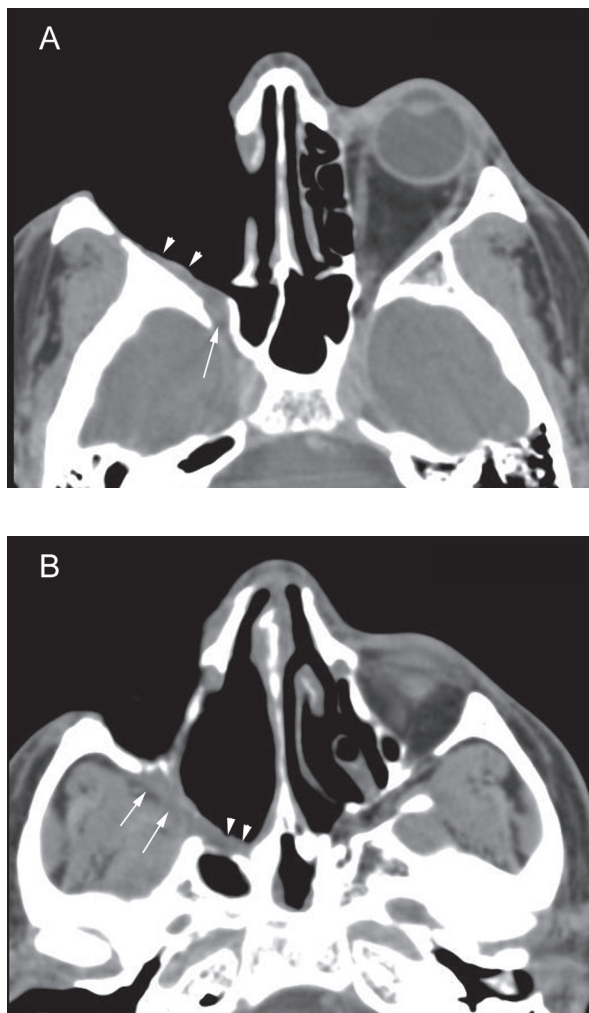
Follow-up non-contrasted axial computed tomographic (CT) images of the affected area obtained after 117 days of posaconazole therapy document significant improvement.
